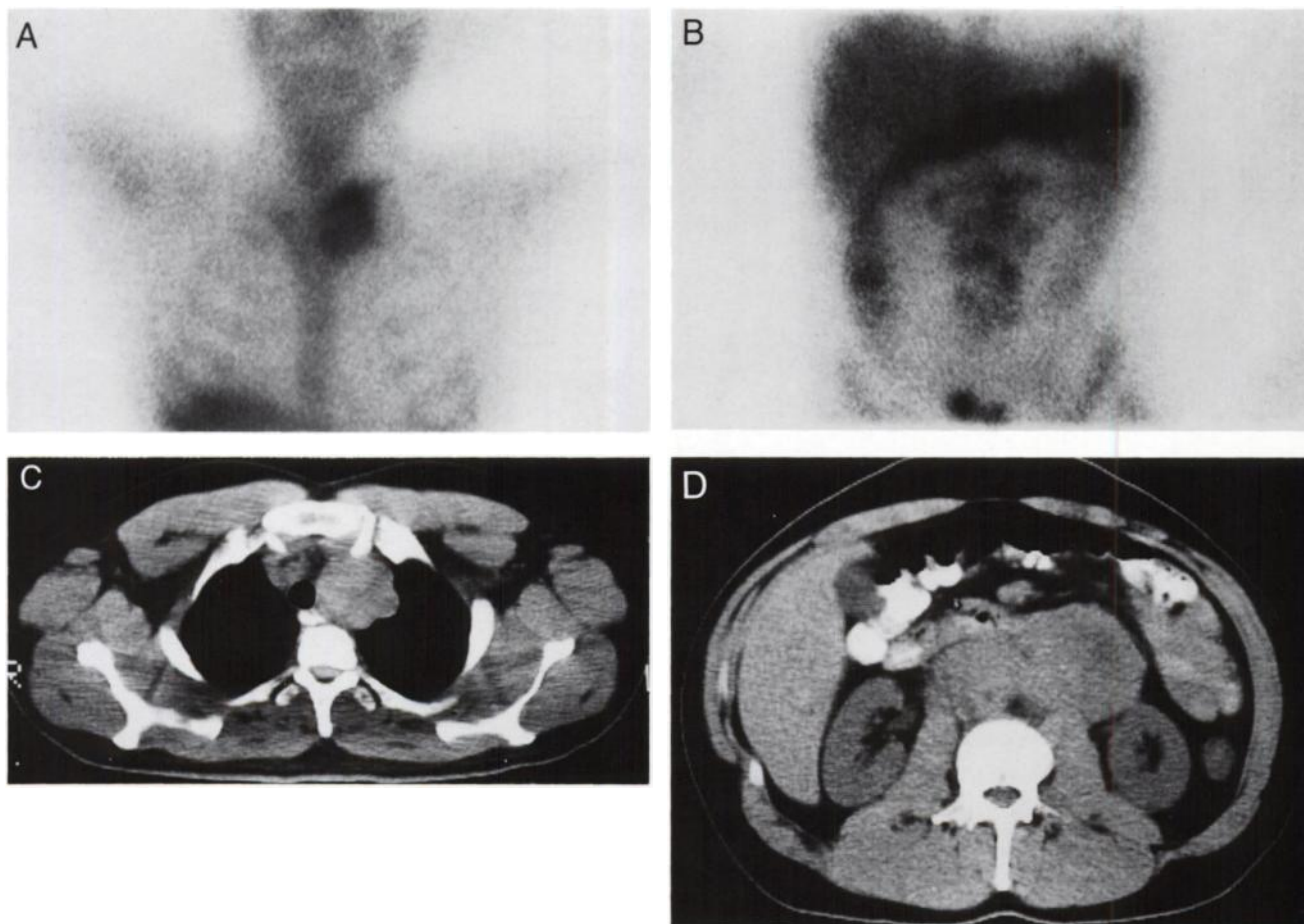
(A–D) Baseline studies of Patient 5, a 36-yr-old man with gonadal seminoma. (A) Gallium-67 imaging of the anterior thorax. Gallium-avid tumor was seen in left supraclavicular and mediastinal region, scored as 6. (B) Gallium-67 imaging of the anterior abdomen. Gallium-avid aggregated tumors were seen in para-aortic region, scored as 5. The uptake in the pelvis disappeared with imaging 144 hr postinjection. (C) CT scan shows a soft-tissue density mass in left supraclavicular and mediastinal region. (D) Huge retroperitoneal masses extended from the level of upper pole of right kidney to the level of bifurcation which surrounded and were inseparable from the vena cava and surrounded the aorta.
